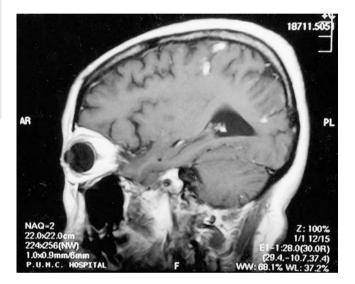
The MRI of the skull showed multiple cerebral infarctions $% \left[{{\left[{{{\rm{T}}_{\rm{T}}} \right]}_{\rm{T}}} \right]_{\rm{T}}} \right]$
